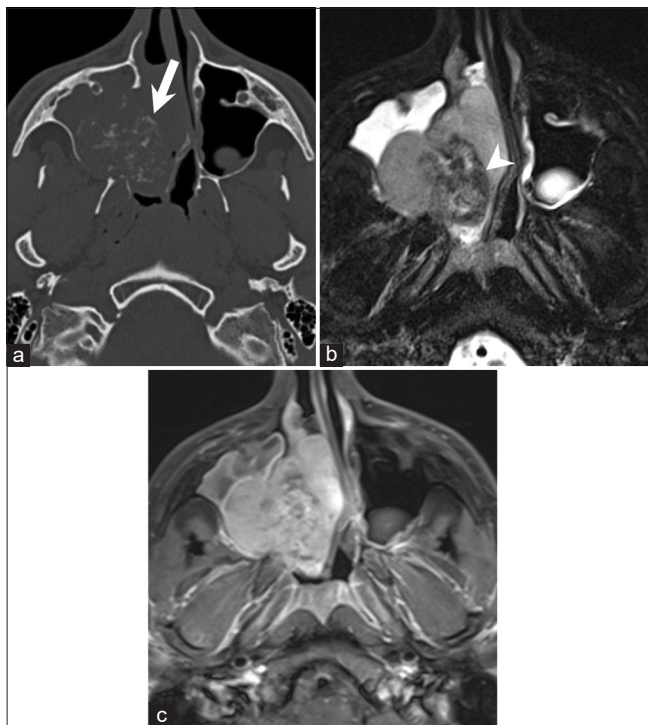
Characteristic CT and MRI features of well-differentiated cartilaginous tumors. A 19-year-old man with sinonasal chondrosarcoma presenting with sinonasal obstructive symptoms. Axial maxillofacial CT image in bone window (a) shows a large right sinonasal mass containing internal ring-and-arc calcifications, a classic feature of calcified chondroid matrix (arrow). The tumor is heterogeneously hyperintense on T2W MRI image (b) and moderately enhancing on post-contrast T1W MRI image with fat suppression (c). Note the T2 hypointense area in the posterior aspect of the tumor (arrowhead in b) corresponding to the area of dense calcification on CT.
